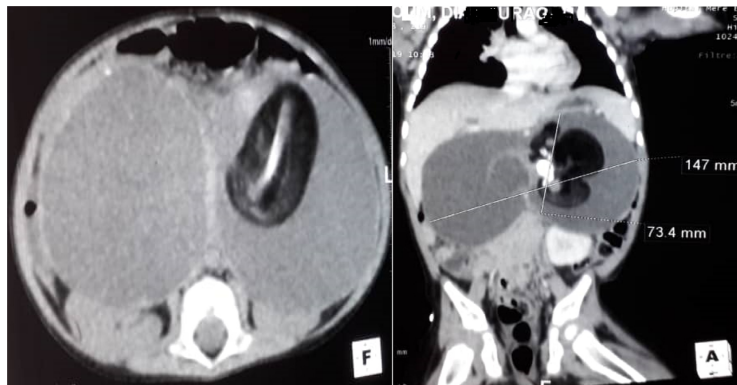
Abdominal CT scan, axial section and coronal reconstruction showing the retroperitoneal teratoma 147 × 73 mm, pushing back the liver and spleen above and the kidneys below.
